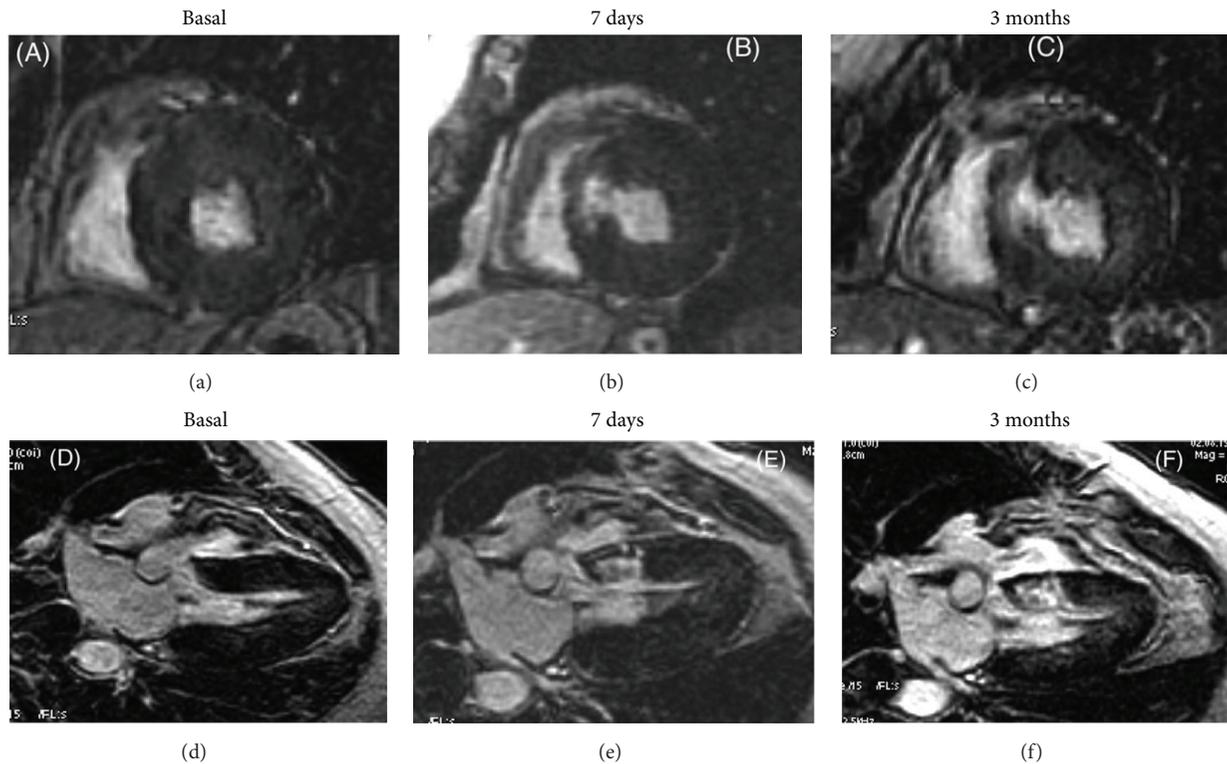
Cardiac magnetic resonance imaging before and after septal reduction therapy (myocardial scar after blockage of septal perforator artery by coil). Example of extension of delayed contrast-enhanced images of patchy areas of hyperenhanced myocardial in the interventricular septum 7 days (b, e) and 3 months (c, f) when compared with baseline (a, d). (a–c) Shot axis view. (d–f) Three-chamber view (reprinted with permission from [65]).
